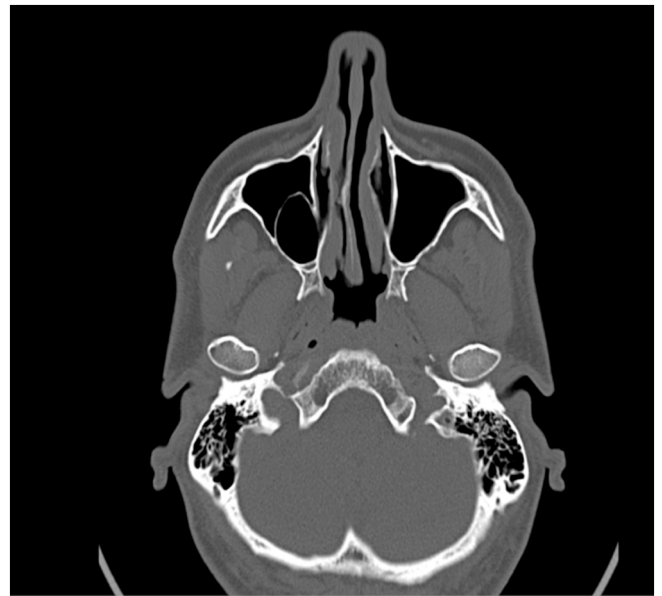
Axial section of CT air cell in the right maxillary sinus with a deviated nasal septum mainly on the right side.
